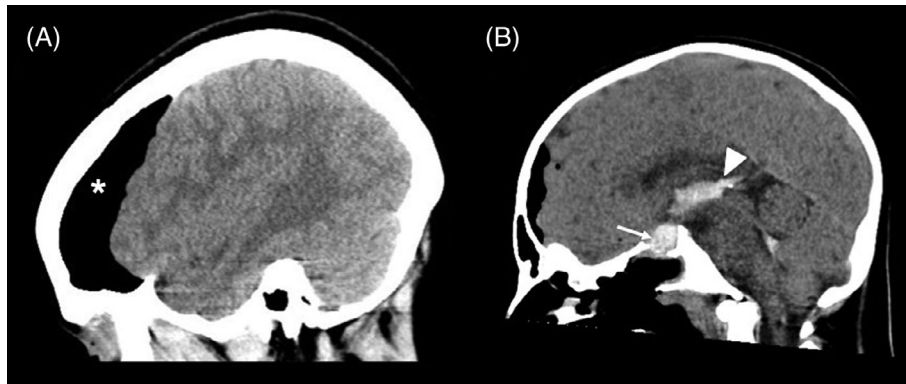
Complications identified on postoperative imaging. A, computed tomography (CT) obtained immediately after sudden onset of headache on a patient 1 day following EEA and resection of a suprasellar teratoma. The patient had a coughing event immediately prior to the onset of headache. Extensive pneumocephalus (asterisk) is noted that was addressed with revision of the skull base repair. B, CT obtained 12 hours after EEA and resection of a sellar and suprasellar craniopharyngioma demonstrates opacification within the sellar cavity (arrow) extending into the ventricular system (arrowhead) indicative of hemorrhage. This patient returned urgently to the operating room for endonasal management of a dura-based bleeding vessel. EEA, expanded endonasal approach
